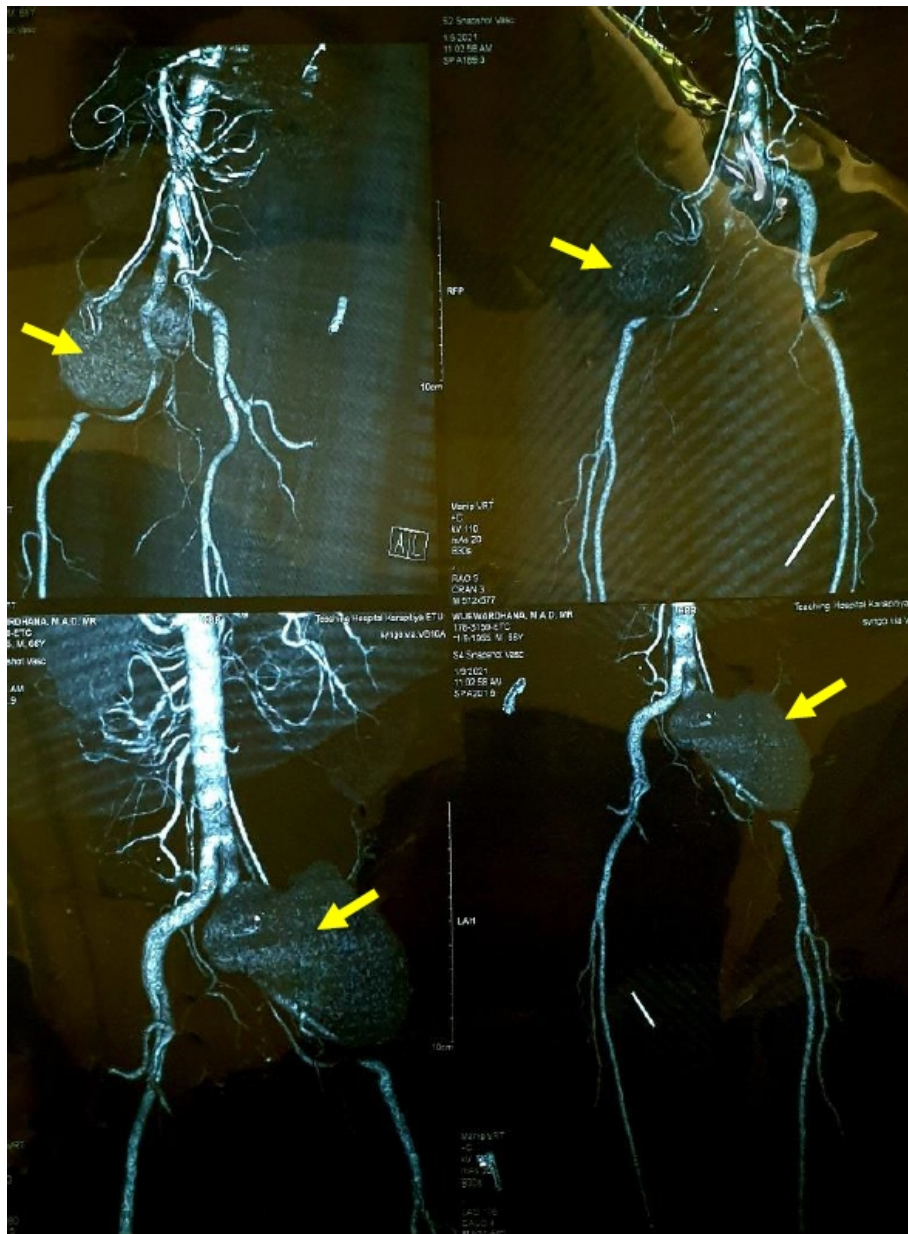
CT angiogram of both lower limbs
